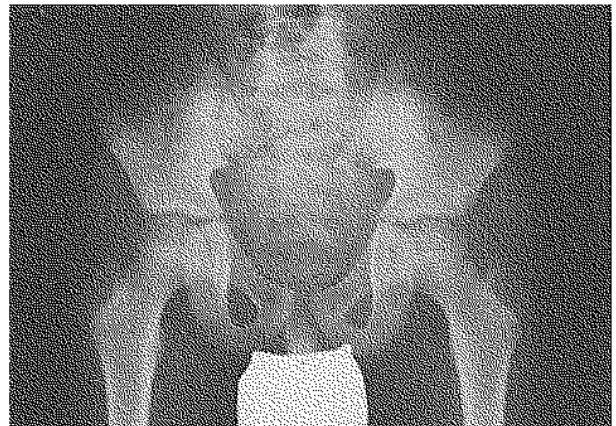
AP radiograph of the pelvis 2 months after onset of symptoms. (Note the small cortical lesion due to the bone marrow biopsy).
